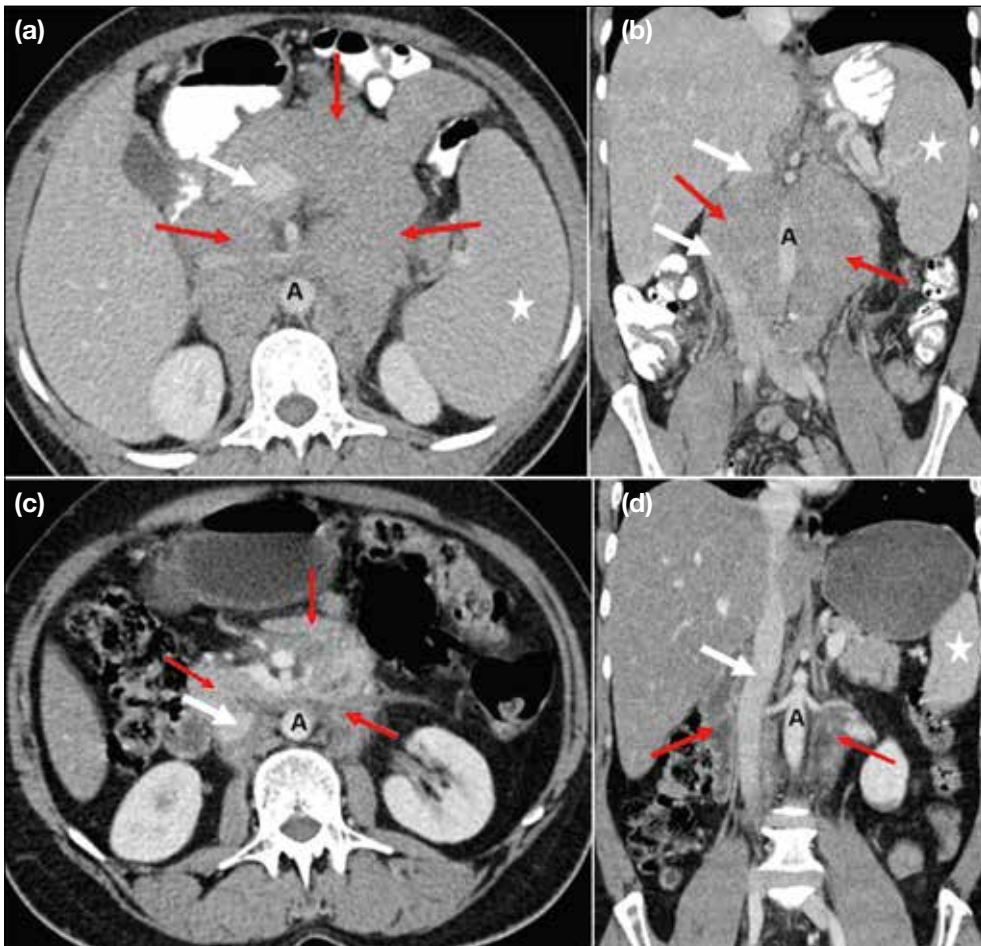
A 24-year-old man with lymphoma. (a) Axial and (b) coronal contrast-enhanced computed tomography images of the abdomen show splenomegaly (stars) and conglomerated nodal mass (red arrows) encasing and causing narrowing of the inferior vena cava (IVC) [white arrows], aorta, and their branches. (c, d) Corresponding post-chemotherapy images show a significant decrease in the size of the nodal mass (red arrows) and spleen (star in [d]), with expansion and visualisation of the IVC (white arrows). Abbreviation: A = aorta.
